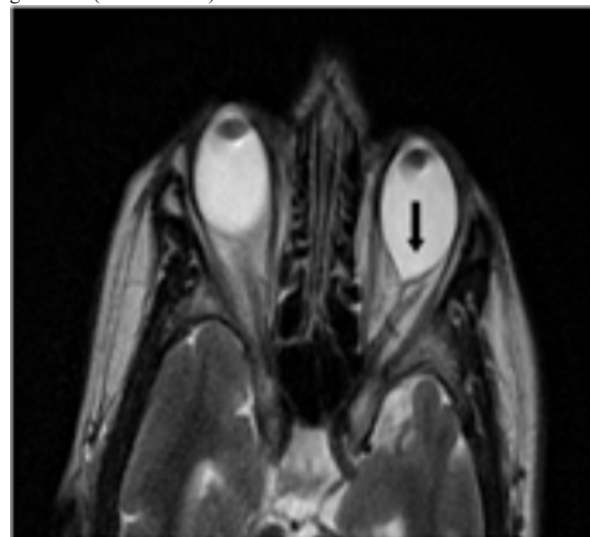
Axial T2WI of MRI brain & orbit showing narrowing of posterior part of left eye ball at the centre suggestive macular staphyloma (black arrow). There is also presence of axial myopia.
